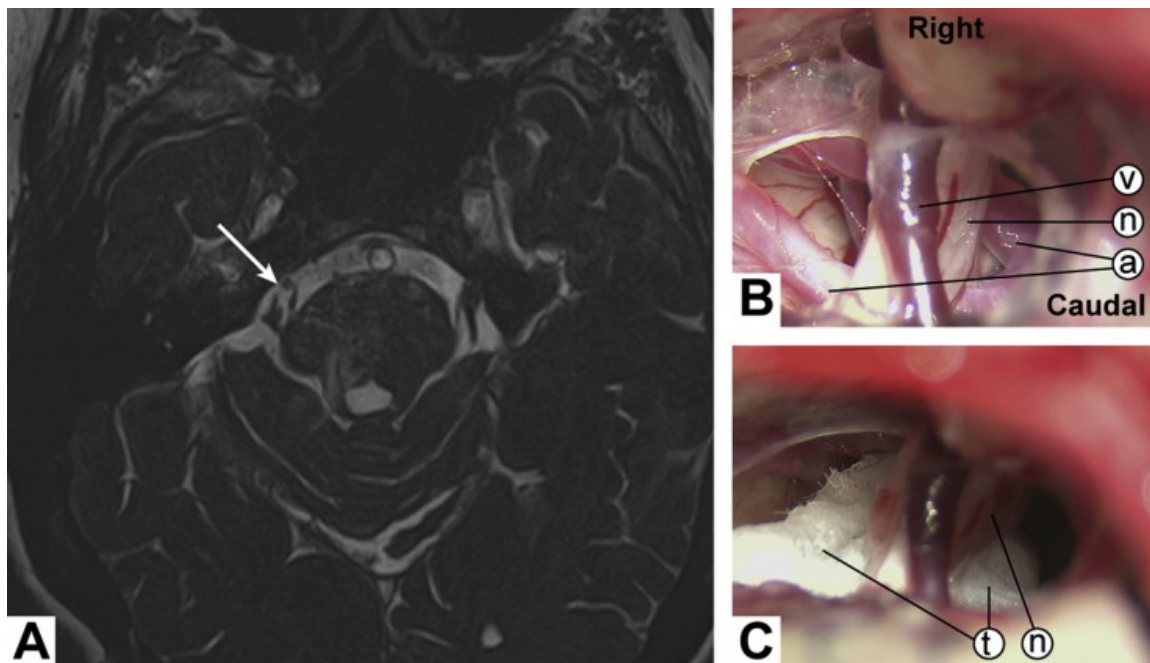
True positive MRI and intraoperative findings showing a NVC.
